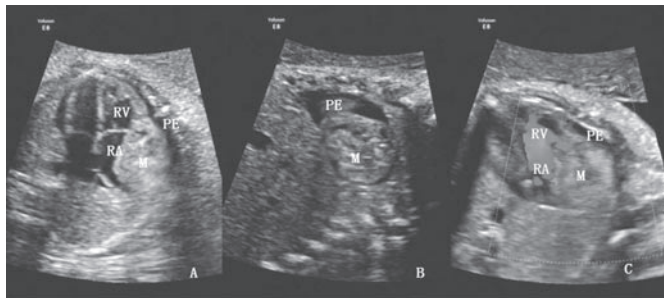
Fetal echocardiographic image. (A, B): 2D imaging shows a mixed echogenic mass arising from the wall of right atrium. Apparent pericardial effusion is present; (C): Color flow imaging show slight obstructive inflow of the right ventricle, but could not show blood flow in the mass. RV, right ventricle; RA, right atrium; M, mass; PE, pericardial effusion.
